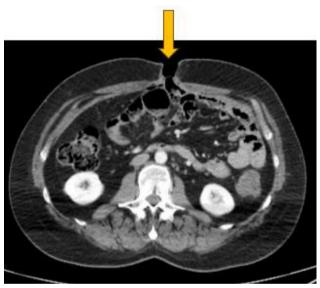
Abdominal computed tomography (CT) showing protrusion of a small bowel loop through the periumbilical stab wound.
